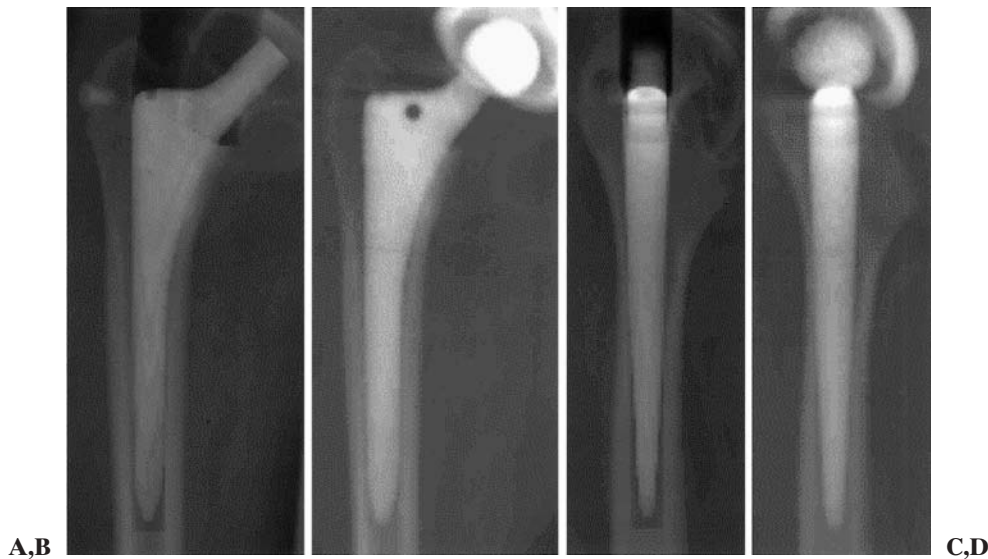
A Anteroposterior synthetic radiograph from preoperative planning. B Anteroposterior synthetic radiograph reconstructed from postoperative computed tomography (CT) data. C Lateral synthetic radiograph from preoperative planning. D Lateral synthetic radiograph reconstructed from postoperative CT data
